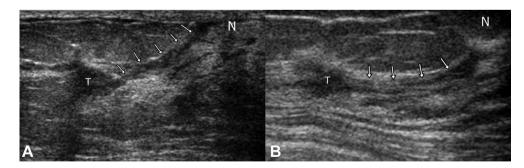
Pipe type: an inhomogeneous hypoechoic lesion located upstream of a dilated lactiferous duct leading to the nipple. The appearance is just like a pipe. (A) Breast sonogram of a high-grade ductal carcinoma *in situ* (DCIS) in the radial axis demonstrated an irregular-shaped hypoechoic lesion (T) connected to the nipple (N) by a dilated lactiferous duct (white arrows) and (B) a low-grade DCIS lesion of the pipe type showed a hypoechoic tumor (T) with a characteristic dilated lactiferous duct (white arrows) extending to the nipple (N).
